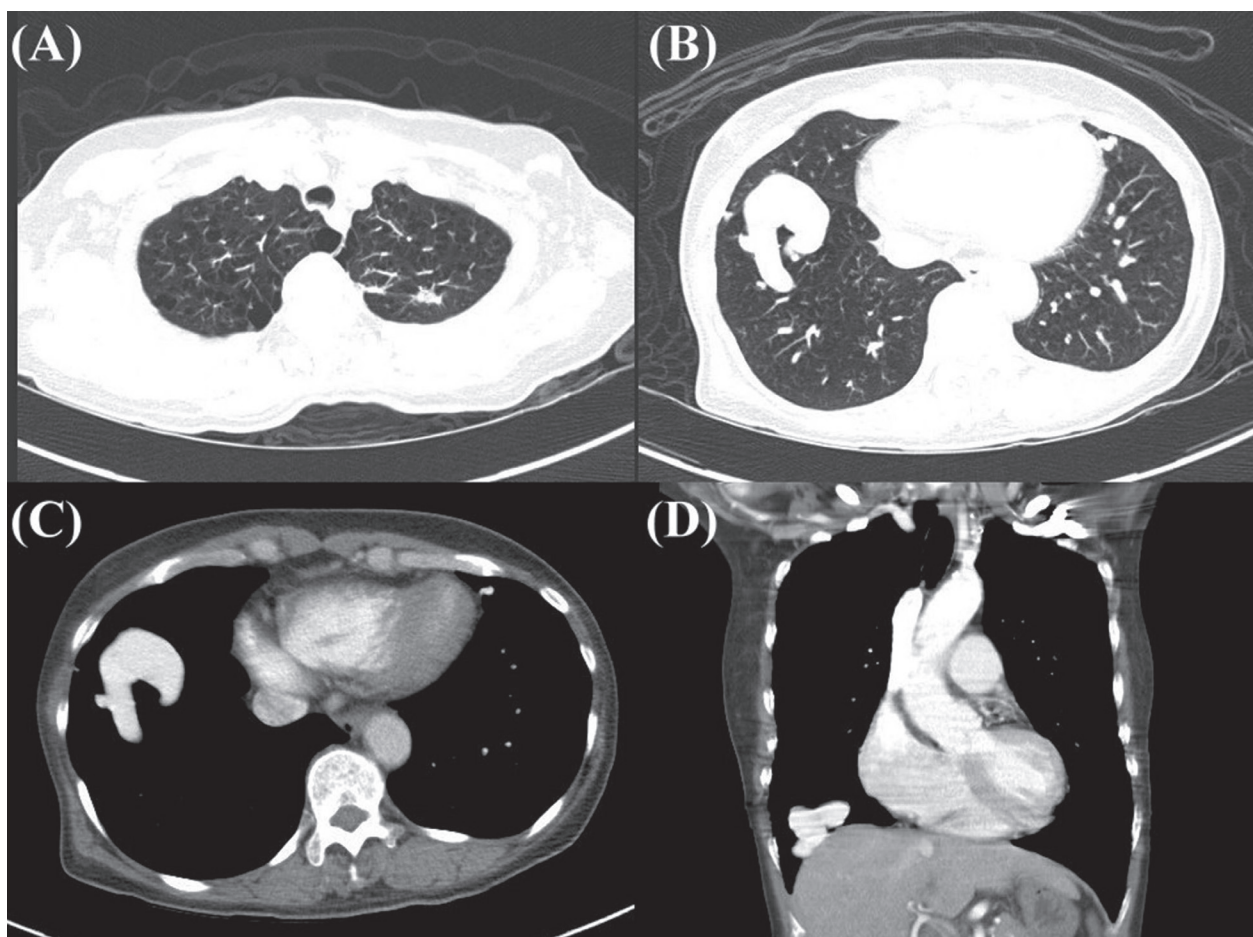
Chest computed tomography scan. (A) Lung window showed emphysematous changes in the bilateral upper lobes and a fibrotic nodule at the left apex, up to 1.2 cm in size, suspected of being sequelae of a previous inflammatory process. (B) In the lung window, pulmonary arteriovenous malformations were found at the anterobasal segment of the right lower lobe and medial segment of the left lingular lobe. (C,D) Transverse and frontal views of the soft tissue window after contrast enhancement.
